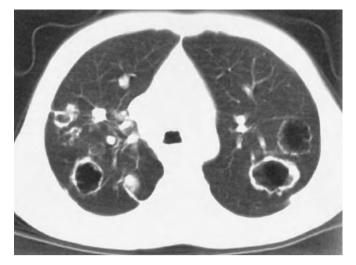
Chest computed tomography scan of an 8-year-old girl with laryngotracheal papillomatosis shows multiple peripheral nodules and cavities with posterior dominance, in keeping with pulmonary dissemination. (From Diagnostic imaging of the respiratory tract. In Chernick V, Boat TF, Wilmott RW, Bush A [eds]: Kendig's Disorders of the Respiratory Tract. Philadelphia, WB Saunders, 2006.)
